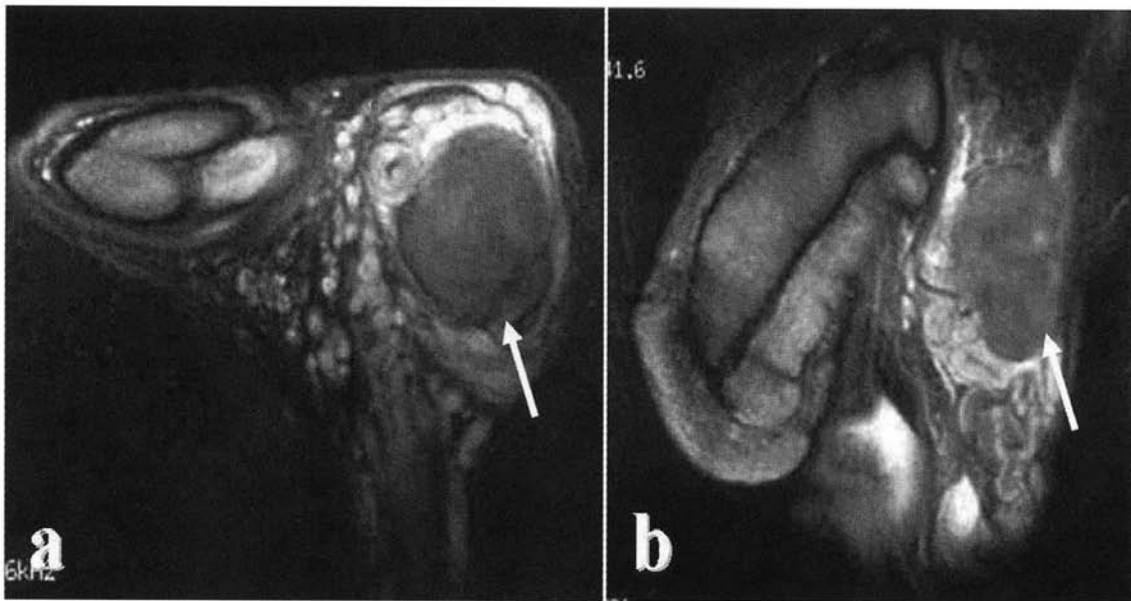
Magnetic resonance image (T2-weighted image) of a smooth margined slightly low-intensity, 35×25 mm round mass (arrow), which involved the epididymis and spermatic cord. a: Axial image b: coronal image.
